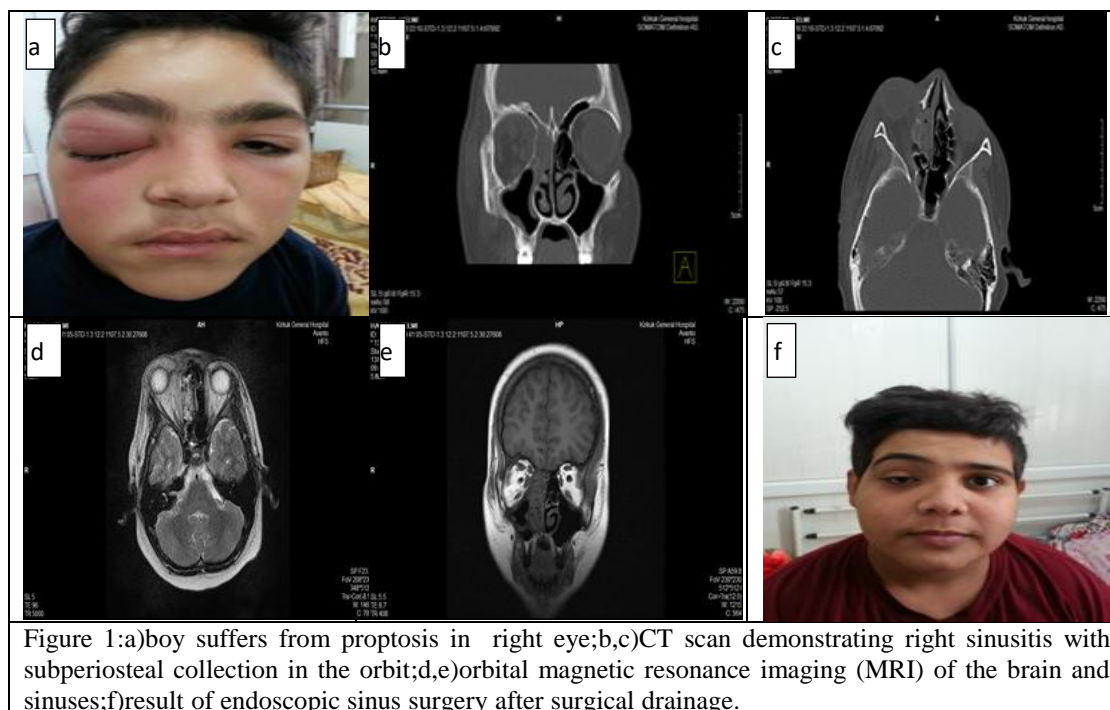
a)boy suffers from proptosis in right eye;b,c)CT scan demonstrating right sinusitis with subperiosteal collection in the orbit;d,e)orbital magnetic resonance imaging (MRI) of the brain and sinuses;f)result of endoscopic sinus surgery after surgical drainage.
